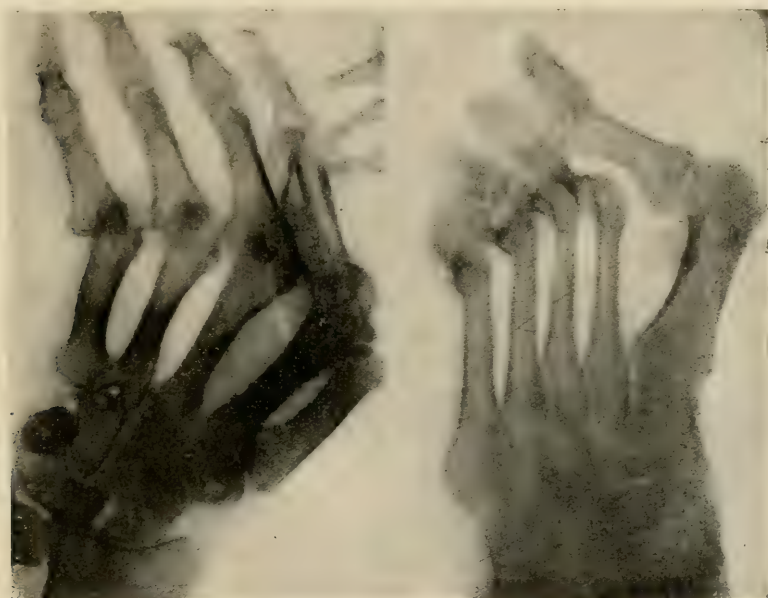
Radiographs of hands of Fig. 488.
